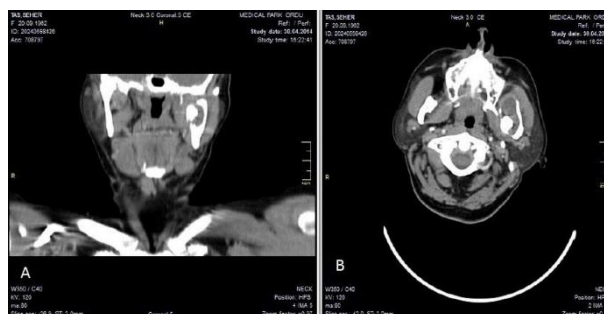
(A) Coronal section of CT scan showing the downward crown position of the ectopic third molar with the proximity to the internal cortical bone of the mandible. (B) Axial section of CT scan showing the ectopic third molar.
